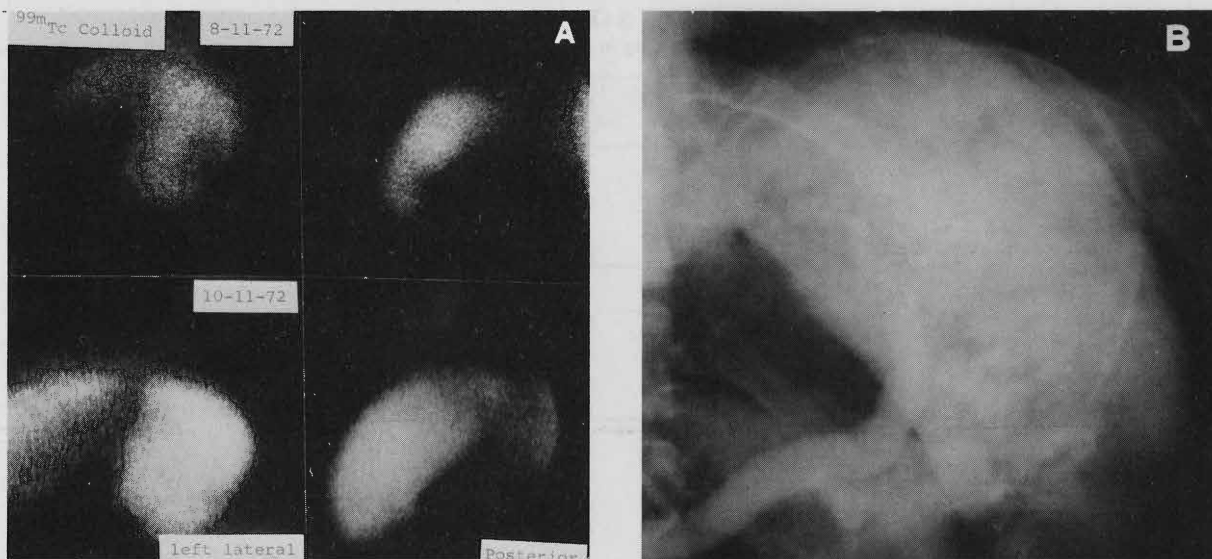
Minor nonsurgical spleen injury in 33-year-old man after stab wound. *A.* A  $^{99m}\text{Tc}$ -colloid study at the time of injury (*top row*) shows a focal area of decreased uptake along the posteromedial border. Angiogram performed at this time is shown in *6B*. Repeat radionuclide study two months later (*bottom row*) in the same left lateral and posterior views show disappearance of the abnormality. *B.* Selective splenic angiogram (late phase) at time of injury in anteroposterior position fails to show the abnormality seen on the scintigraphic study. Apparent lucencies over the lower portion of the spleen represent bowel gas.
